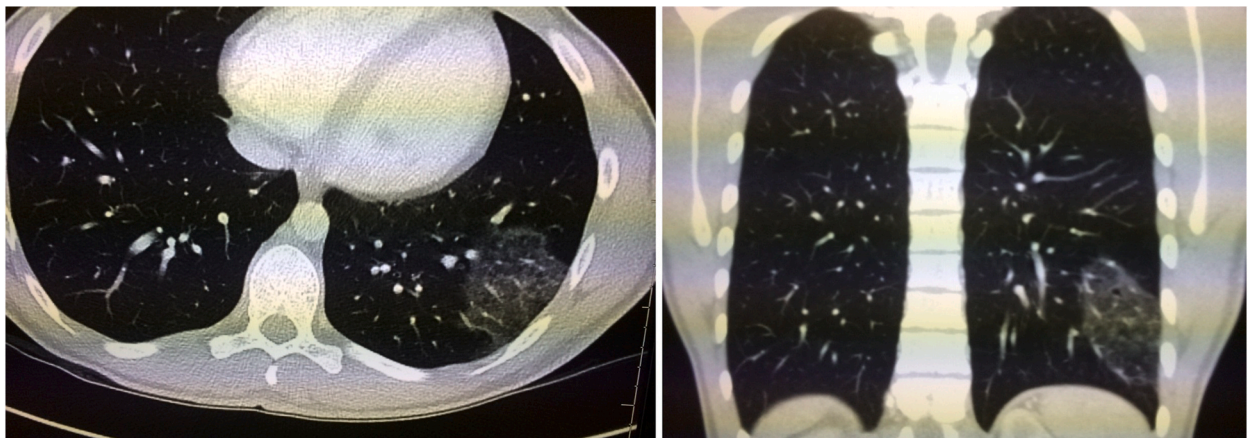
Computed tomography scan, lung windows, in both axial (left) and coronal (right) planes showing focal, non-segmental areas of parenchymal opacification at the site of injury, consistent with pulmonary contusion. In the axial plane, a small rim of pleural sparing is visible, a typical feature in pulmonary contusion.
